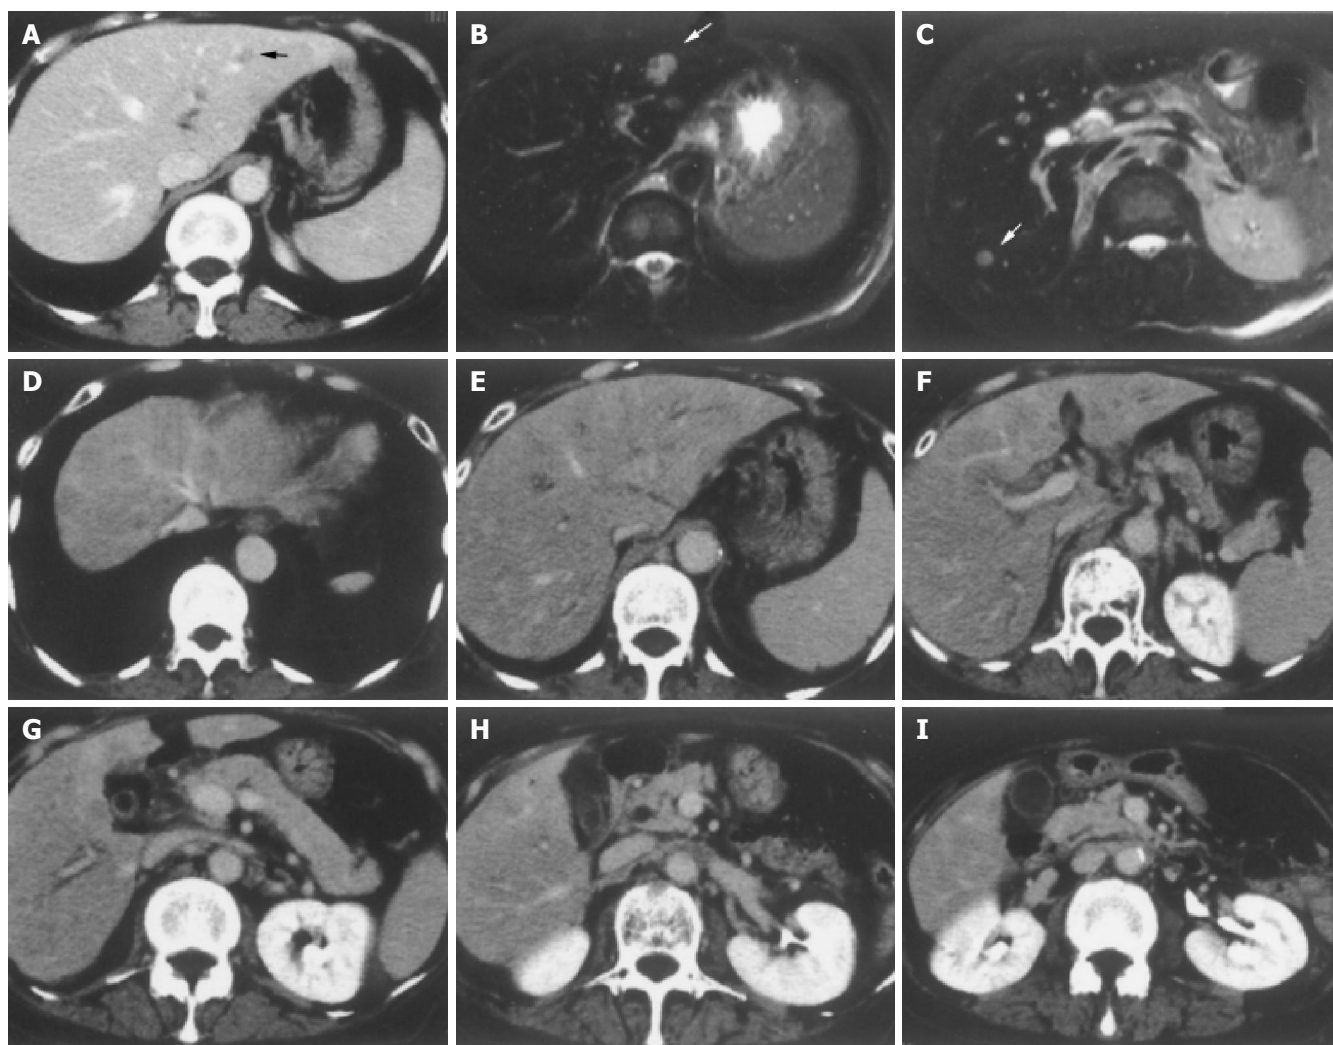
A: Enhanced CT scan on April 2, 2003. A metastatic lesion in liver S₂ (arrowhead). B and C: Enhanced magnetic resonance image with Ferridex on May 19, 2003. Metastatic lesions in S₂ (B, arrowhead) and S₆ (C, arrowhead).
